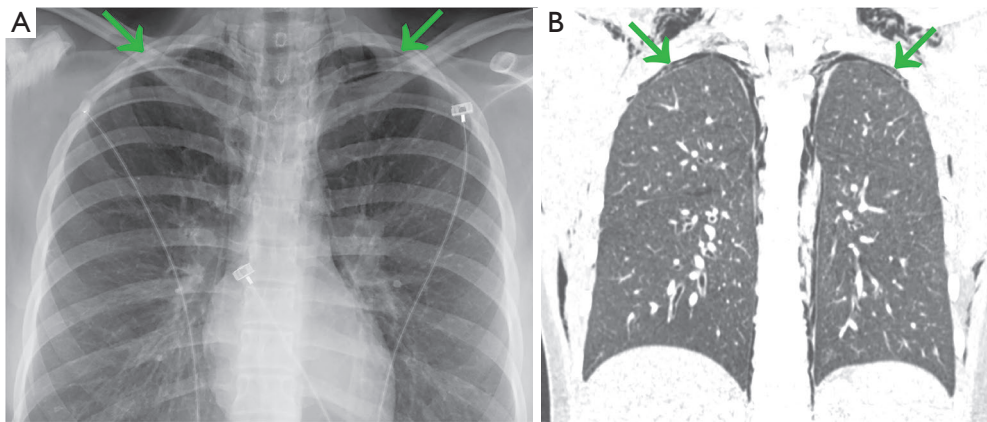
Pseudopneumothorax in patients with PSPM. (A) CXR chest demonstrating pseudopneumothorax in a patient with PSPM. Note the gas under the parietal pleura (green arrows). (B) CT chest demonstrating pseudopneumothorax (green arrows) in the series.
